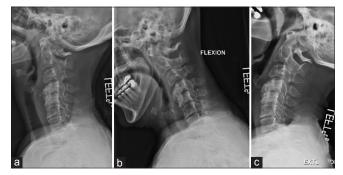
A 57-year-old female with cervical myelopathy; preoperative lateral X-rays: (a) neutral; (b) flexion; (c) extension
